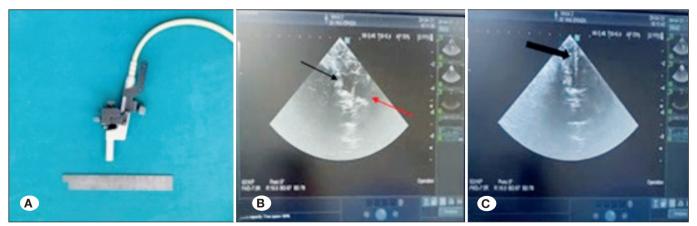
A) The burr hole probe used in the intraoperative ultrasonography. B) Visualization of the lateral ventricles with intraoperative ultrasonography (black arrow: right lateral ventricle, red arrow: left lateral ventricle). C) Neuroballoon catheter view in the right lateral ventricle (thick black arrow).
